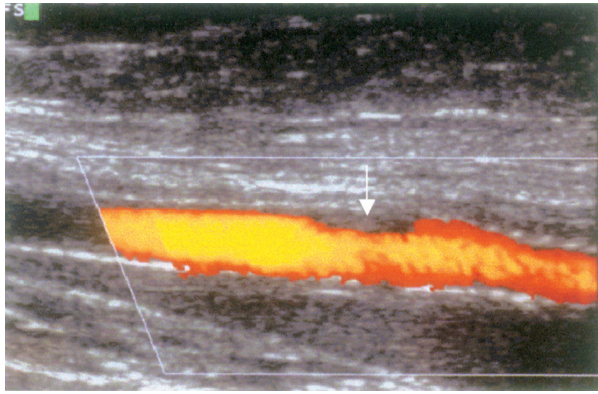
Intimal hyperplasia (arrow) with low echogenicity after stent implantation in the superficial femoral artery (power Doppler US).
